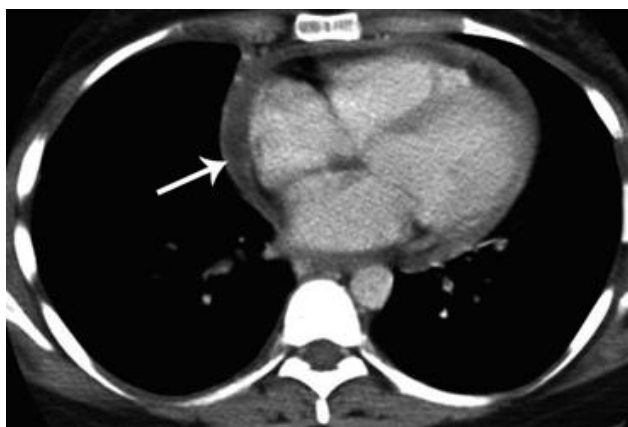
Axial contrast-enhanced CT scan shows pericardial effusion (white arrow)
